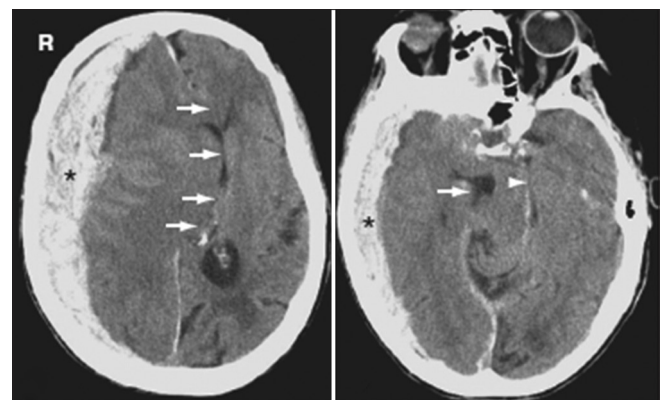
Acute subdural hemorrhage (SDH). Axial computed tomographic images show a large right holo-hemispheric high-attenuation extra-axial collection (asterisk). The SDH causes (a) severe right-to-left midline and subfalcine herniation (arrows), (b) medial displacement of the right temporal horn (arrow), and right uncus herniation (arrowhead)
